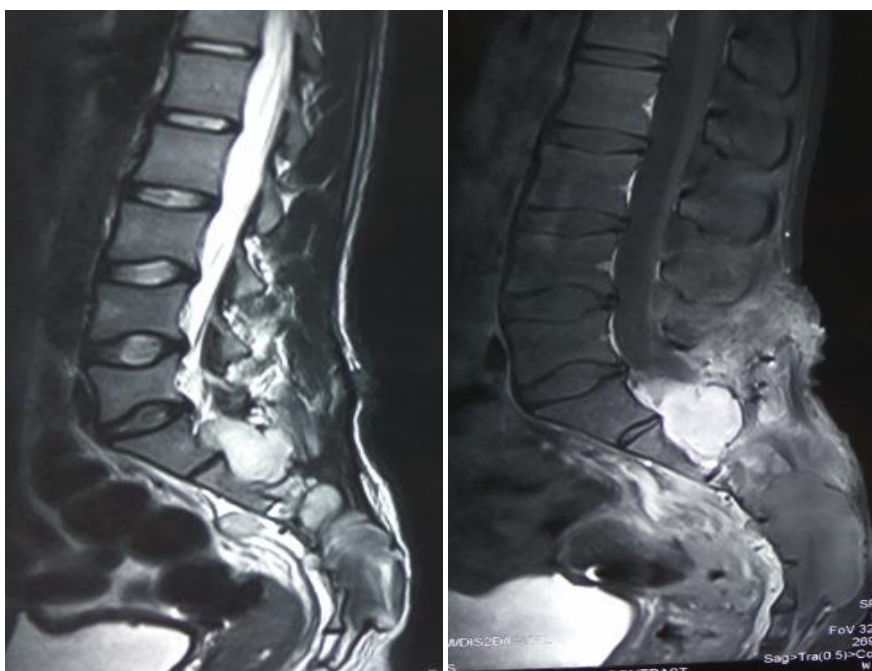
Sagittal MRI (T1W and T2W with ontrast) showing sacral mass with posterior extension of Evan's tumor
